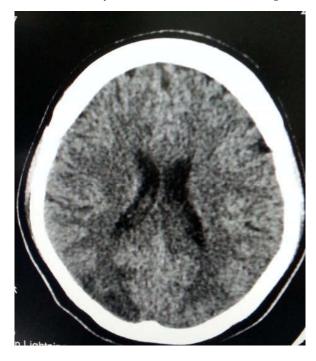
CT brain axial view showing hypodensity in bilateral parietooccipital region
